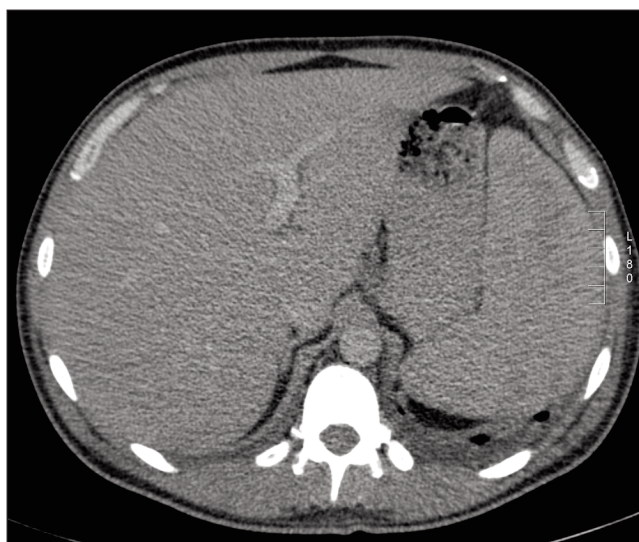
CT image of the abdomen shows significant hepatosplenomegaly
